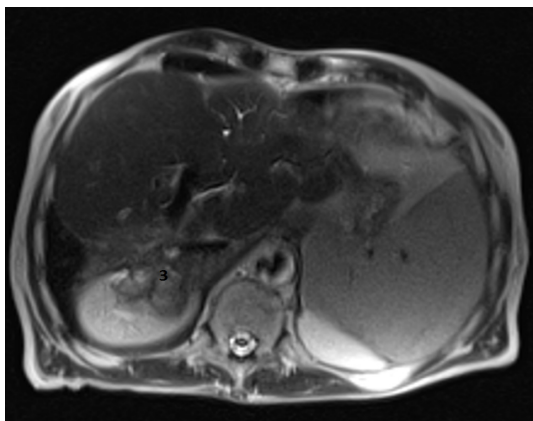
Liver magnetic resonance imaging. Axial T2-weighted imaging HASTE magnetic resonance imaging. Multiple irregular right liver metastatic lesions (3).
